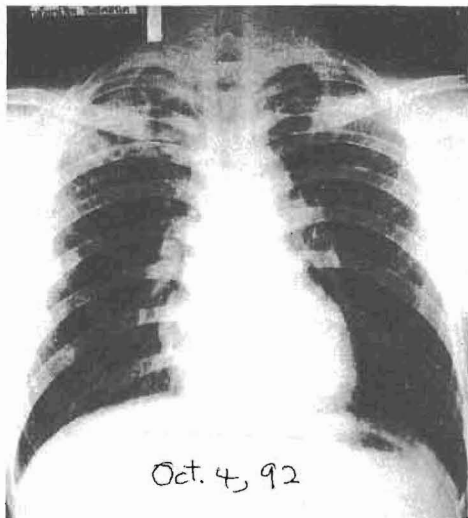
A postero-anterior chest radiograph taken on October 5, 1992, showing discrete opacities over both upper lung fields with multiple small cavities.
